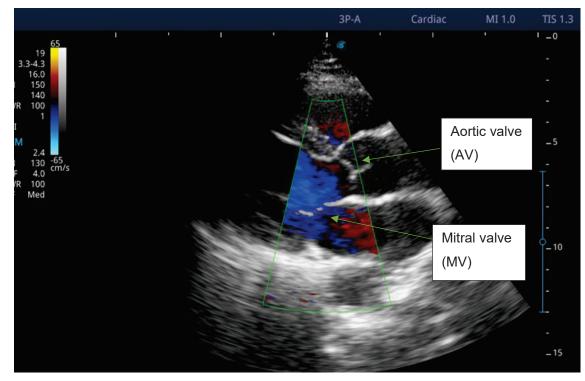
Colour Doppler flow velocity of the MV and AV
